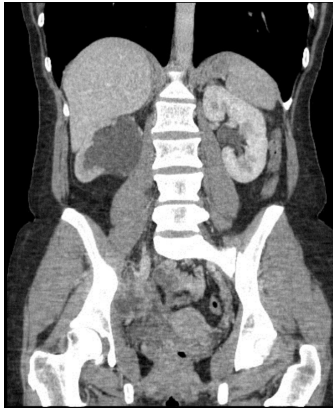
Computed tomography: coronal view.
